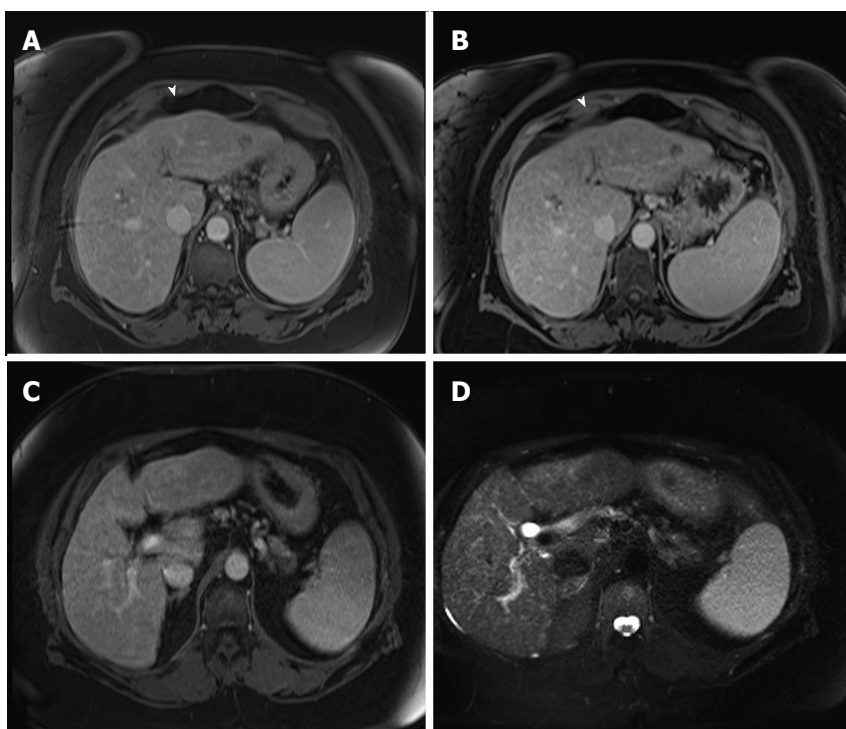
Arterioportal shunt. Post-contrast fat-suppressed 3D-GRE T1-weighted images during the late hepatic arterial (A and B) and delayed phases (C); D: Fat-suppressed SSFSE T2-weighted image. There is a convoluted linear area of increased arterial enhancement with a vessel leading to it (arrowhead, A, B), which does not demonstrate delayed washout (C), or corresponding T2 signal abnormality in keeping with an AP shunt. SSFSE: Single-shot fast spin-echo; GRE: Gradient recalled echo.
